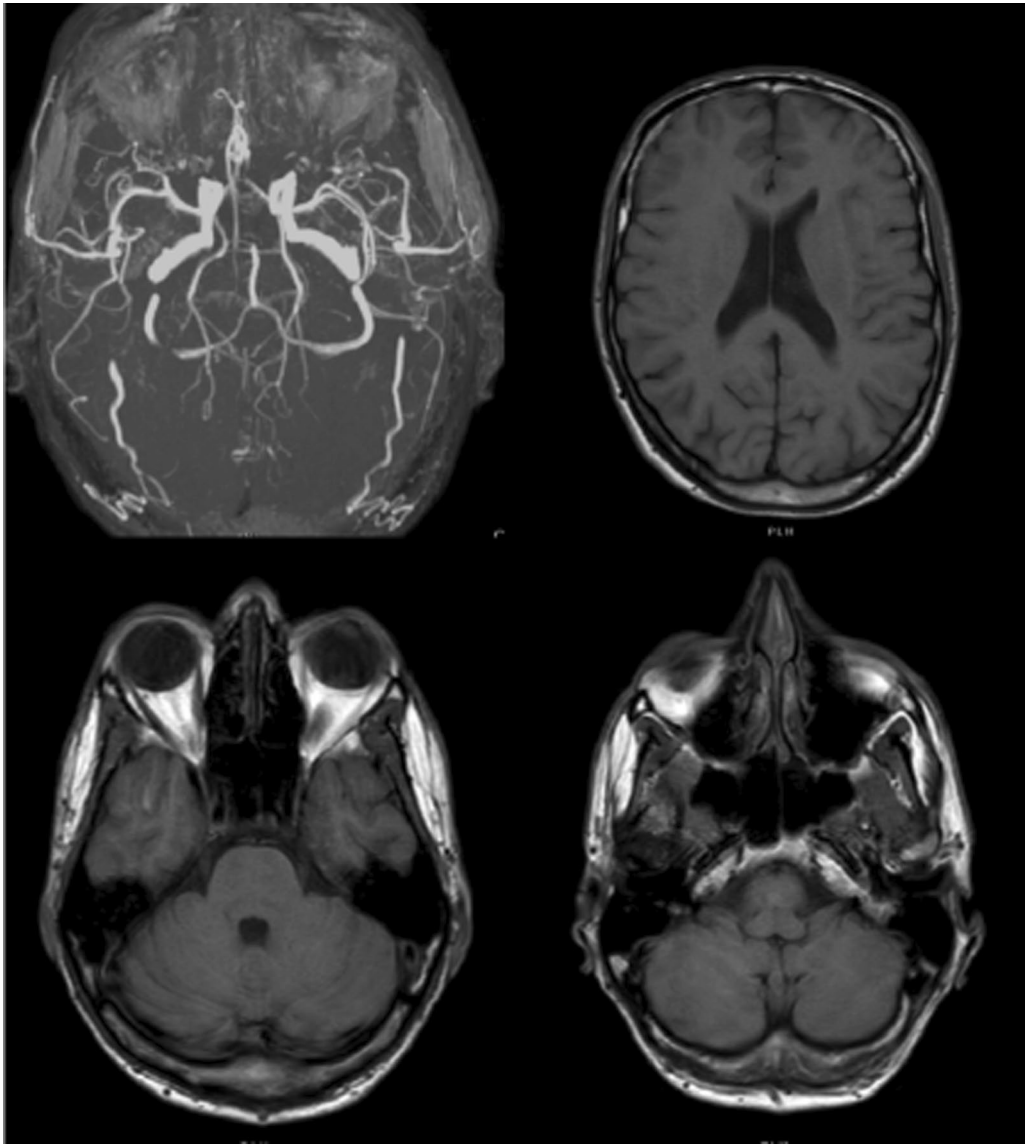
Patient's magnetic resonance imaging. Angio and T1-weighted sequences
